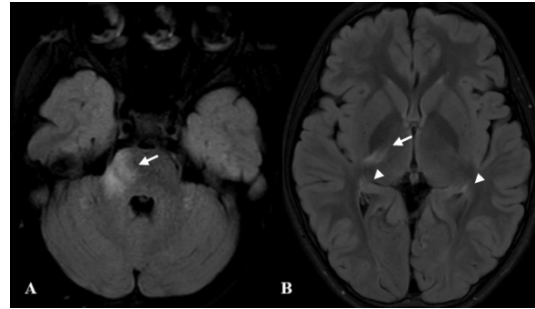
Axial FLAIR brain MR image (A, arrow) of a 4-year-old female patient diagnosed with NMOSD shows expansive increased signal consistent with an encephalitis focus extending from the right half of the brainstem to the peduncular area. Follow-up axial FLAIR brain MR image (B, arrow) obtained at 6 years of age shows complete regression of the brainstem-located lesion (not shown), but increased signal consistent with new foci of encephalitis, prominent in the posterior limb of the right internal capsule (arrow) and faint at both posterior peritrigonal areas (arrowheads).
